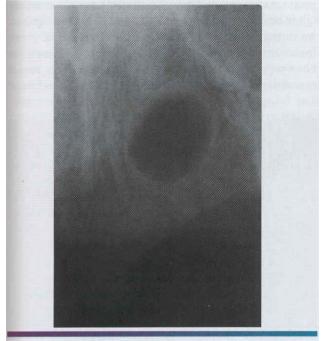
Figure $3\cdot 30$. Residual periapical cyst. Persistent radiolucency of the mandi bular body at site of previous tooth extraction.
